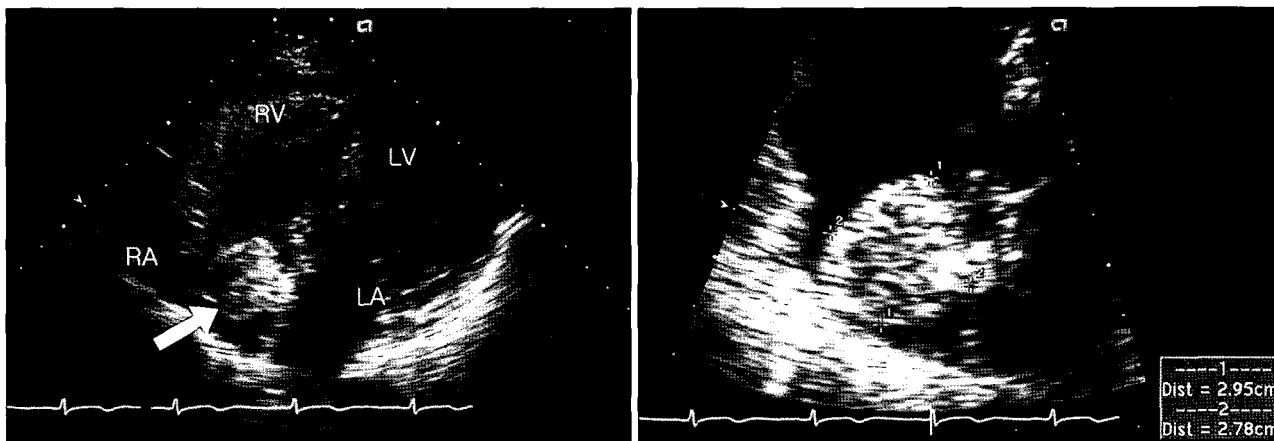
TTE apical four chamber view (left) and magnification (right) show the mass (white arrow) about 30 mm in diameter in the right atrium. The mass was attached to the atrial septum by short pedicle. LA=Left atrium; LV=Left ventricle; RA=Right atrium; RV=Right ventricle.
